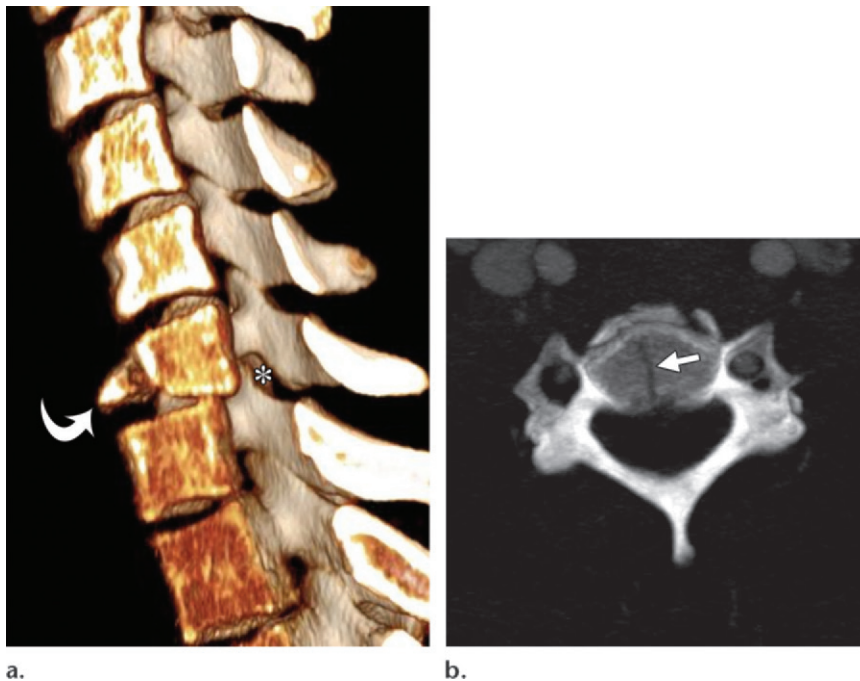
Translation injuries: flexion teardrop injury in a 27-year-old woman who was a victim of assault. (a) Sagittal half-space slab volume-rendered CT image shows the flexion teardrop injury pattern, with the classic findings of a triangular fragment (arrow) off the anterior inferior C6 vertebral body and posterior translation of the vertebral body and posterior elements, resulting in facet widening (*). (b) Axial MIP image shows a sagittal fracture line (arrow) through the C6 vertebral body posterior to the teardrop fragment.
